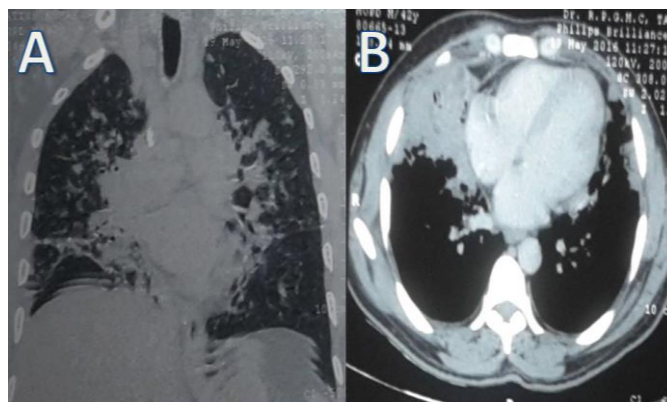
A) Coronal CT (lung window) B) axial CT (mediastinal window) showing multiple ill- defined nodular densities, ground glass opacities with patchy areas of consolidation
